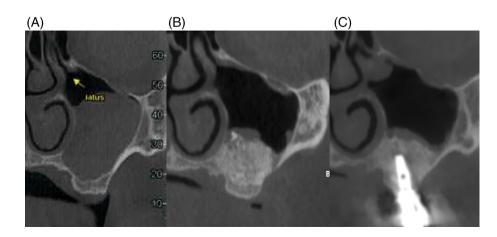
Cross sections view of the same case shown in Figure 3 (A) Pre-op CBCT, (B) Post-Op CBCT, (C) 5 Years follow up a minimal thickening of the sinus membrane is visible.
